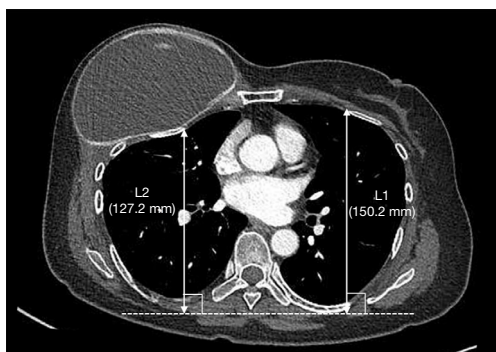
Preoperative CT image. CWD can be identified on the right chest; the antero-posterior length of the right chest wall was 127.2 mm and that of the left side was 150.2 mm. L1: preoperative left chest wall; L2: preoperative right chest wall. CT, computed tomography; CWD, chest wall depression.
